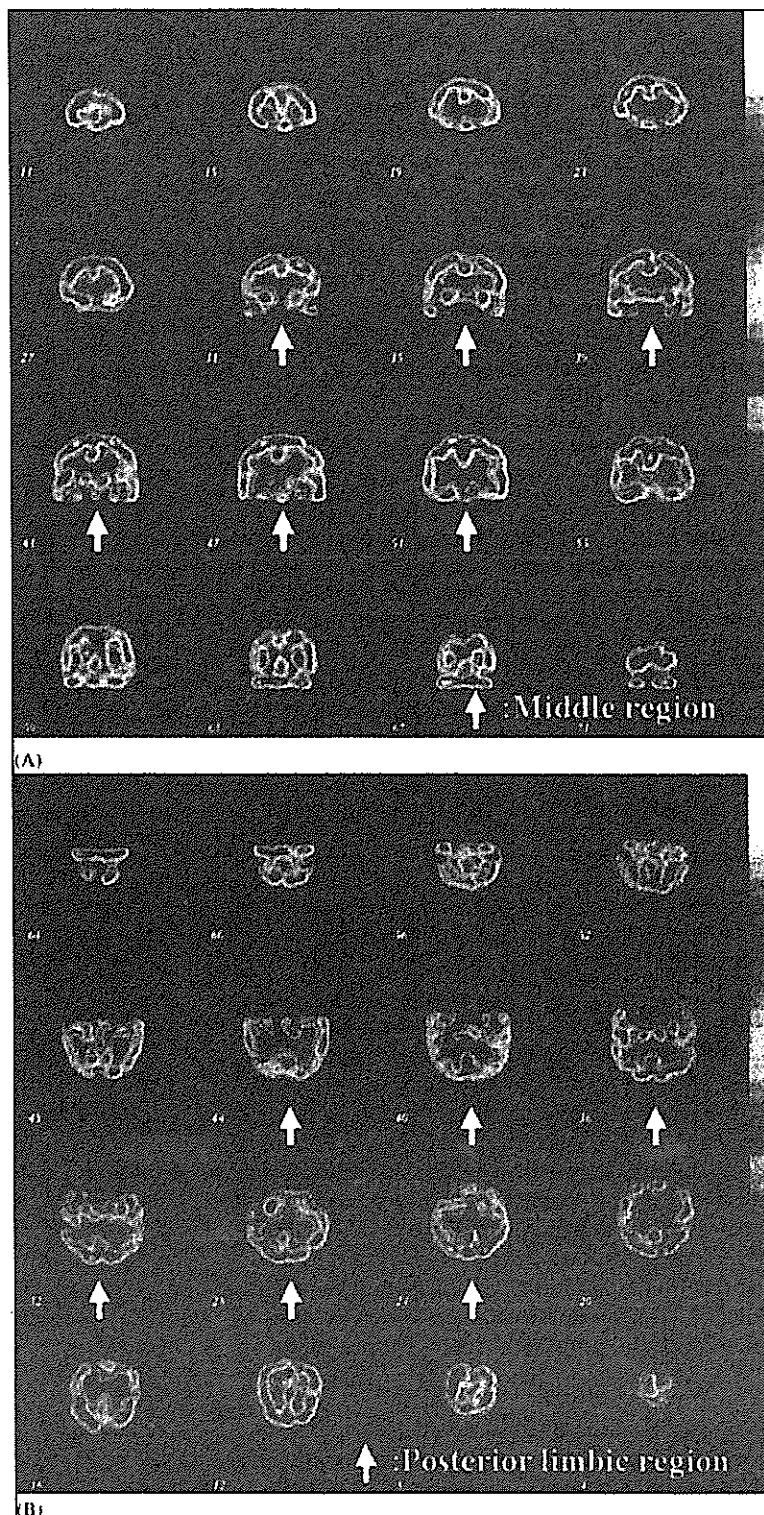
(A) The coronal SPECT images for a 69-year-old female with very early Alzheimer's disease show no definite hypoperfusion area. The arrows indicate the slices corresponding to the middle region. Her anterior fractal dimension (FD), middle FD and posterior FD were 1.00, 0.98, and 0.78. (B) The SPECT images were reconstructed at 30° positive to the coronal plane, the same case as (A). The arrows indicate the slices corresponding to the posterior limbic region. Her posterior limbic FD was 1.07.
